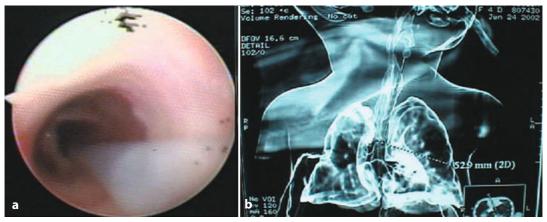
Tracheal agenesis. A catheter inserted in the TEF in the distal tract of the trachea (a). CT (gap from upper stop and the TEF) (b)
